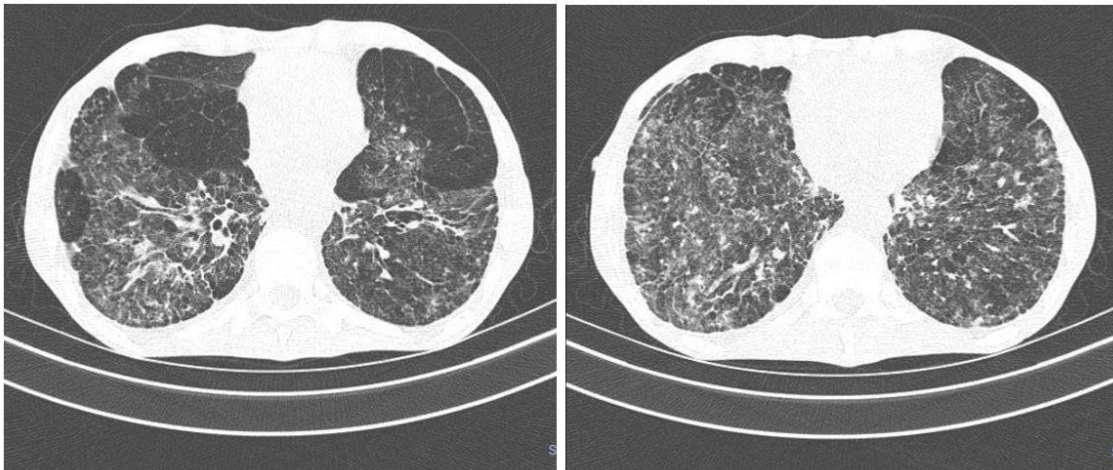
CT images with sections of the upper 1/3 of the lung structure showing diffuse thickening of the bronchial walls, indicating chronic bronchopathy and discrete centrilobular nodules, sometimes confluent.
